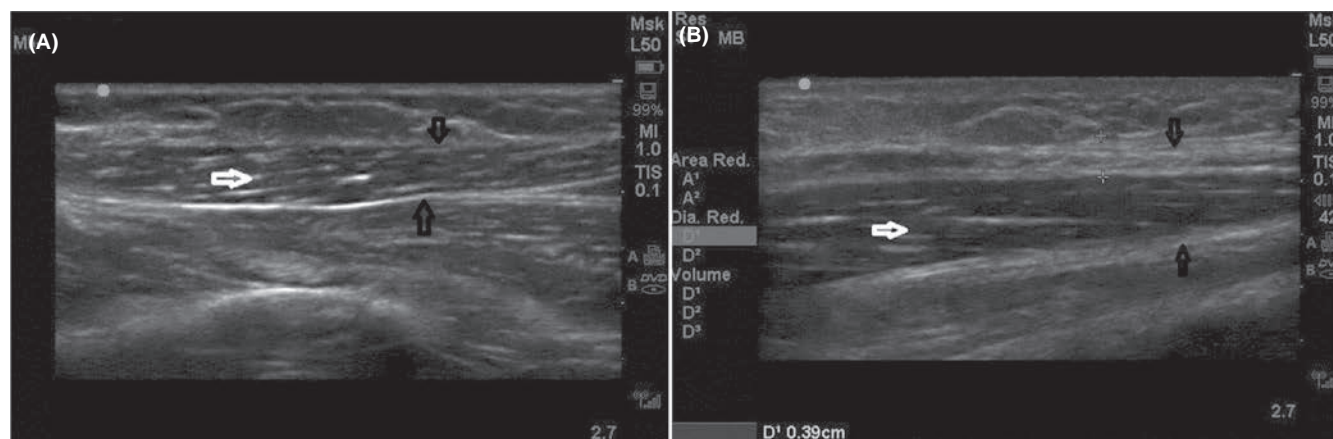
Musculoskeletal Ultrasound. (A) Transverse view of normal forearm muscle. White arrow indicates normal muscle; black arrows, normal fascia. (B) Transverse view of forearm muscle with eosinophilic fasciitis. White arrows indicate normal muscle; black arrows, thickened fascia
